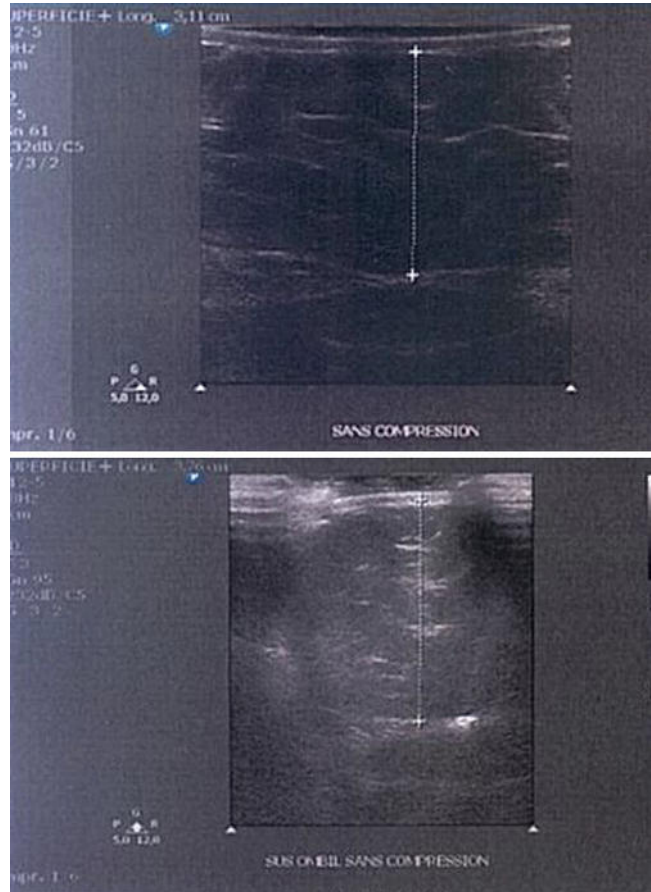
Ultrasound assessment of subcutaneous fat thickness. This example demonstrates reduction in subcutaneous fat thickness from a thickness of 37 mm (before, shown as top image) to a thickness of 31 mm (after, shown as bottom image) 1 month following a series of six noninvasive RF treatments.
